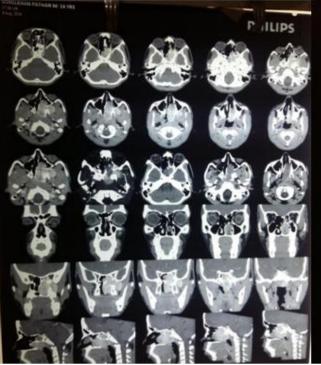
Above is the CT scan of another case of our study which was having stage 2 juvenile angiofibroma.
